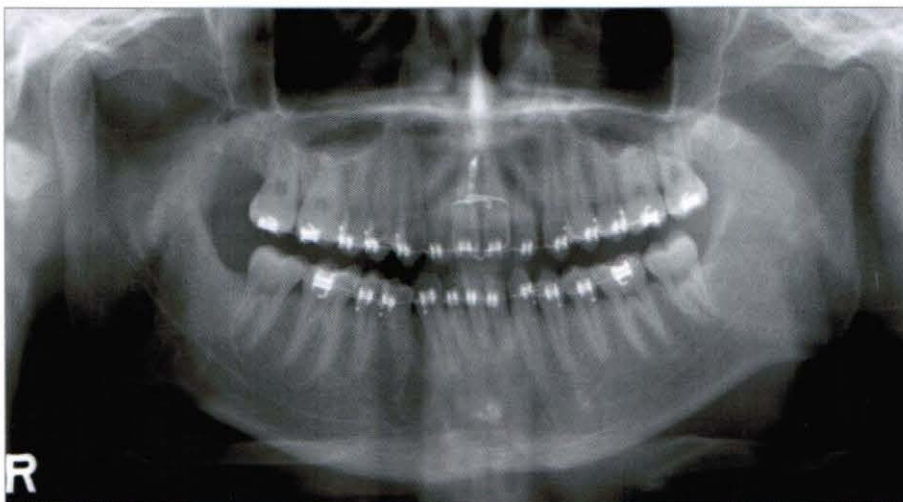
Panoramic radiograph eight months after intrusion of the central incisors (2006, 4,5). No abnormalities such as root resorption are observed.
